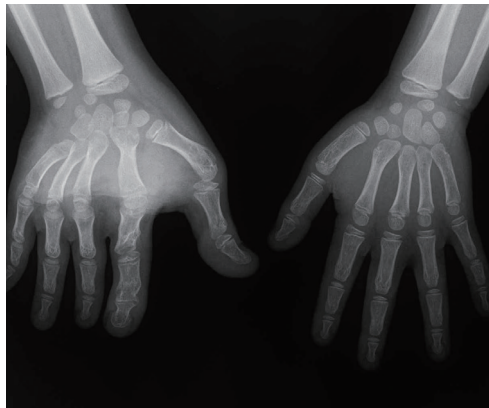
X-ray at age six, with correction of clinodactyly and epiphysiodesis allowing the control of index finger overgrowth.
